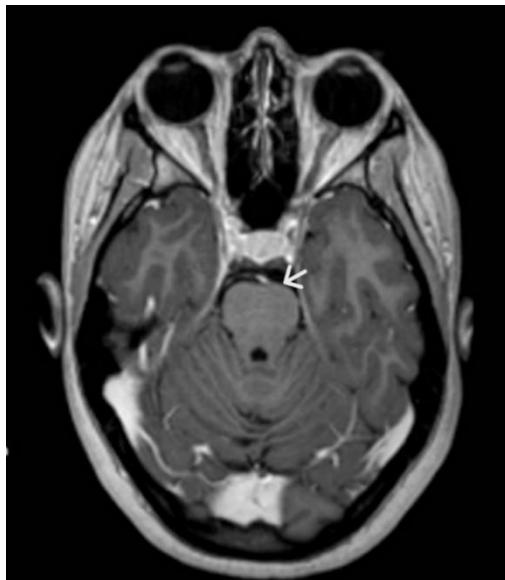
MRI shows an enlarged Pituitary gland.
